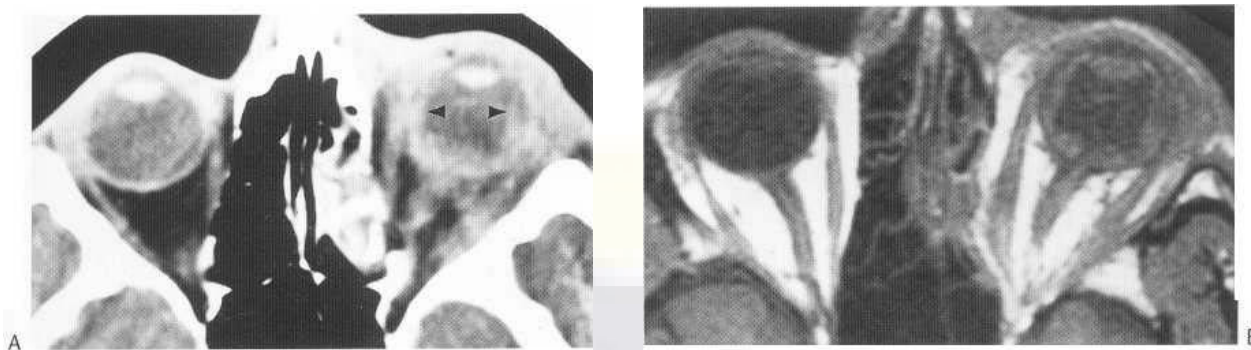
Trauma with blow-out fracture and choroidal detachment. Axial CT image (A) demonstrates preseptal soft-tissue swelling as well as infiltration of retro-orbital fat representing contusion. Elevation of choroid (arrowheads) is due to hyperdense suprachoroidal haemorrhage. Opacification of left ethmoid sinuses is related to medial blow-out fracture. Axial T₁-weighted MR (B) confirms presence of suprachoroidal blood.
